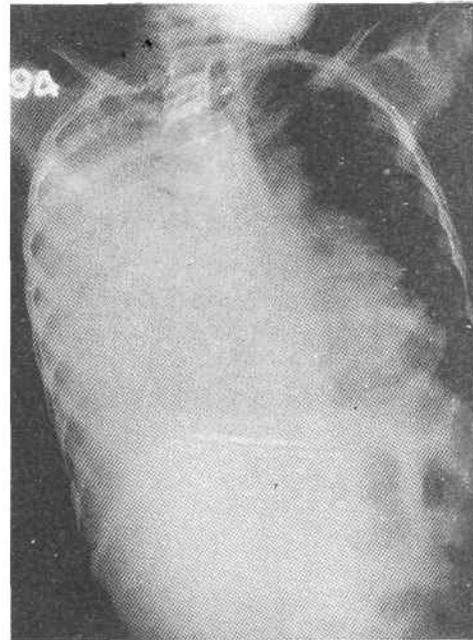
X-ray chest showing opacity of the right hemithorax with mediastinal shift.
